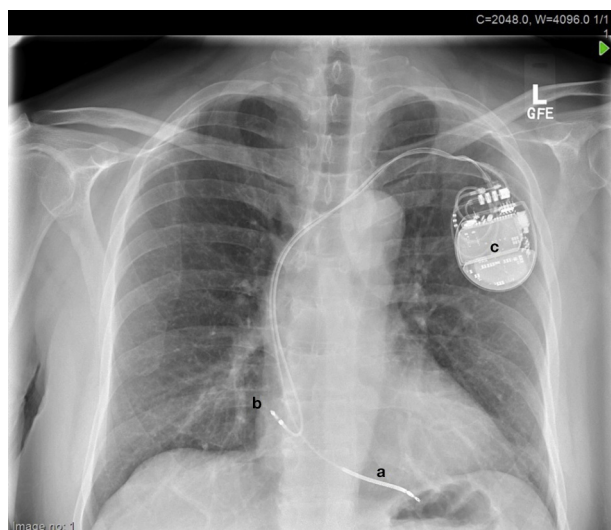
Postero-anterior chest radiograph demonstrating an ICD. (a) defibrillation coil, (b) right atrial lead, (c) ICD pulse generator.
